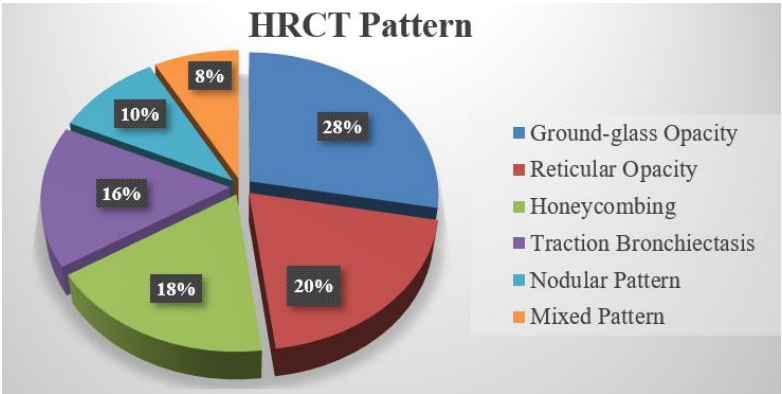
1. Distribution of HRCT Patterns in ILD Patients
